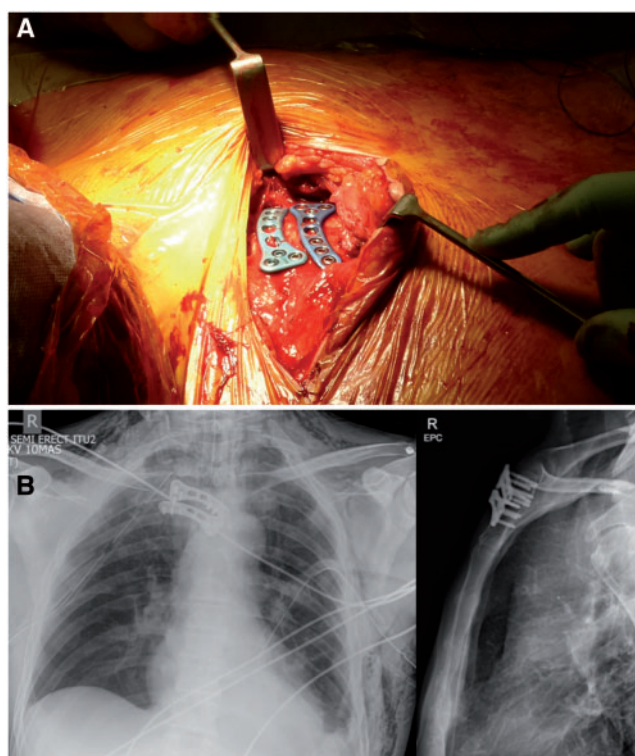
(A) Arrangement of distal clavicular plates. (B) Postoperative X-rays.
